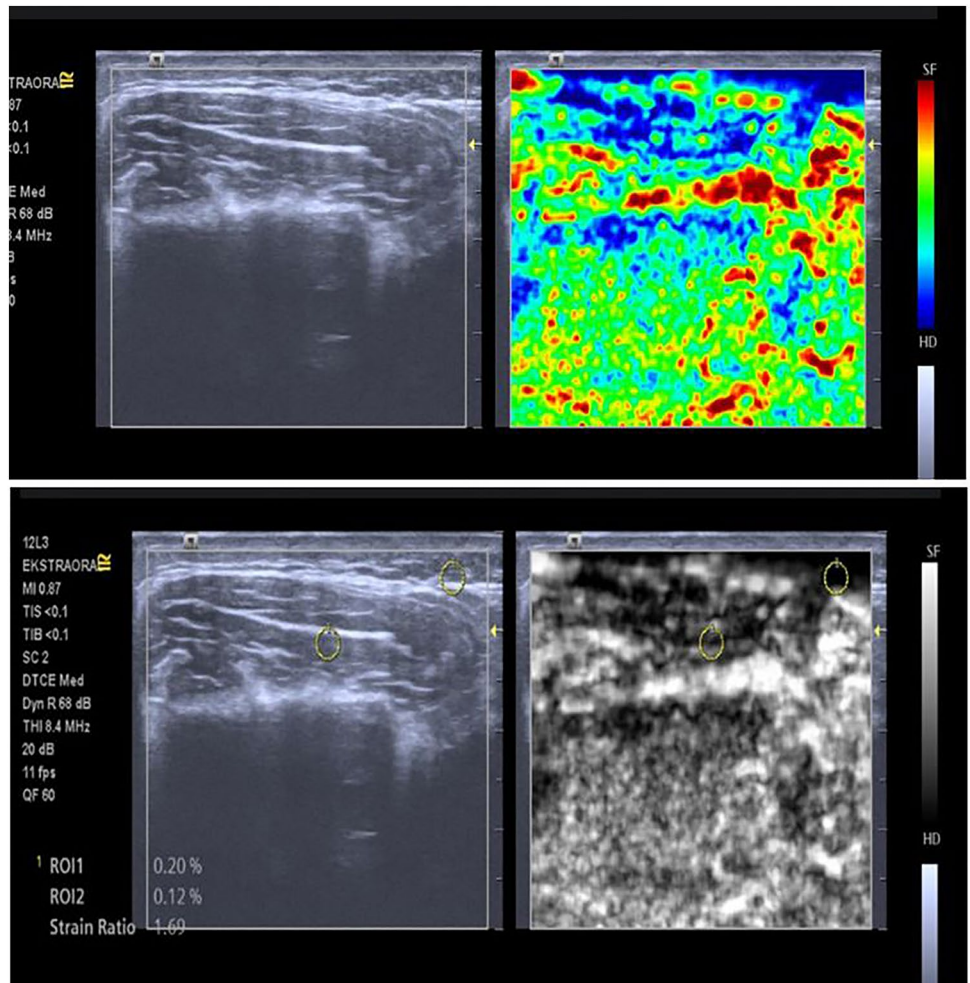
Evaluation of TMJ elastography in ultrasonography
